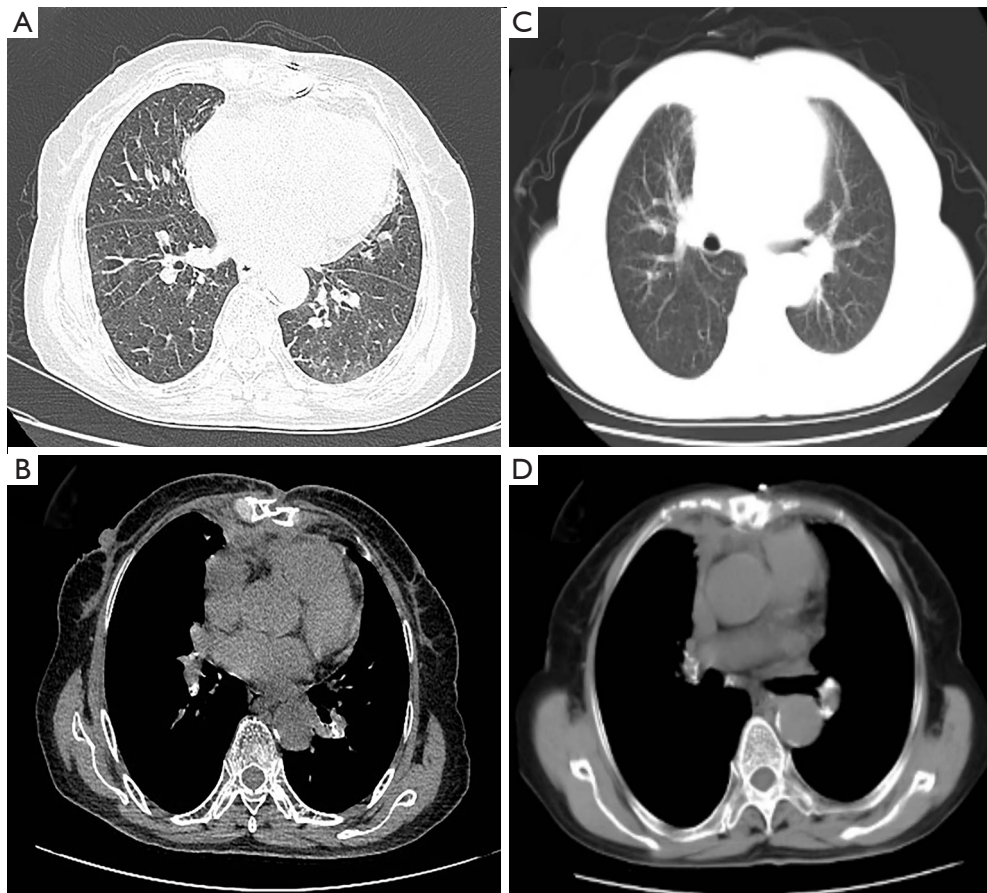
Patient's postoperative chest CT imaging. (A,B) Postoperative tumor recurrence was not observed in the patient; (C,D) postoperative imaging demonstrating the absence of abnormal soft tissue-density masses in the anterior mediastinum and enlarged lymph nodes. CT, computed tomography.
